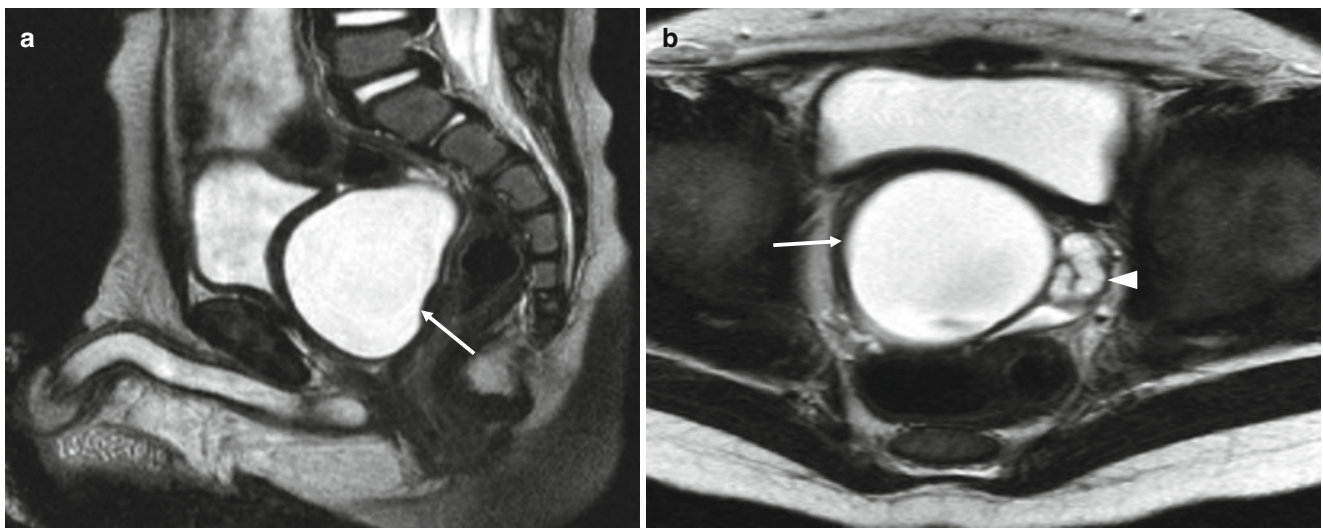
Utricle in a 2-year-old male. (a, b) Sagittal (a) and axial (b) T2-weighted MR images show a midline cystic mass (*arrows*) in the rectovesical pouch. The dilated seminal vesicles (*arrowhead*) are displaced due to utricle cyst
